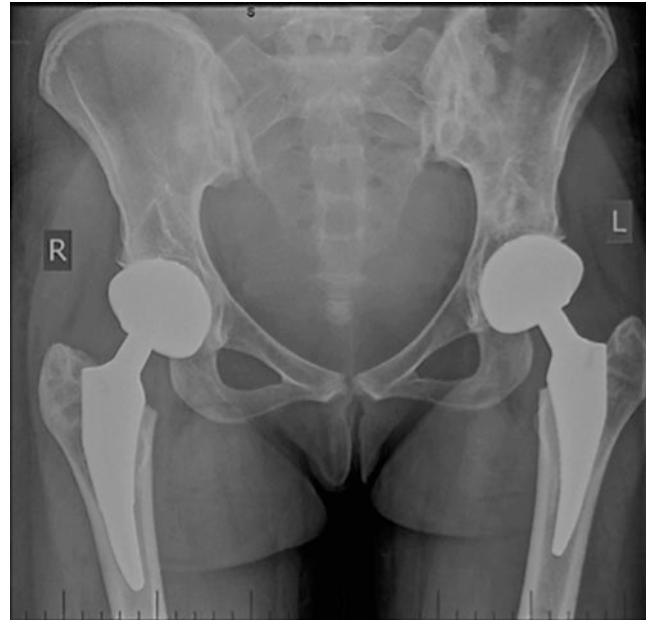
Postoperative AP radiograph of the pelvis and hips, demonstrating bilateral uncemented THAs in excellent position
